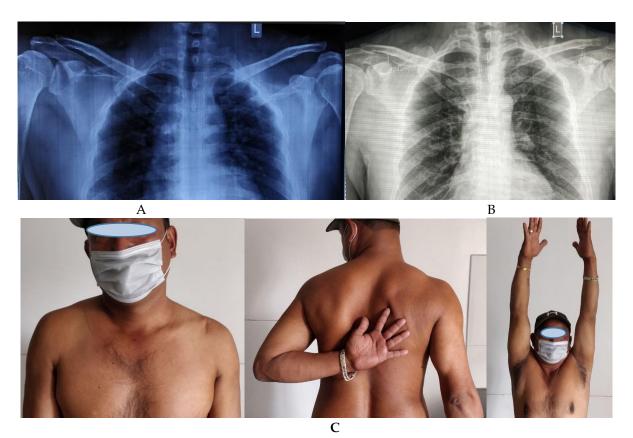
A. Pre-operative AP radiograph showing type V AC joint dislocation of left side; B. Final follow up (19 months) AP radiograph showing reduced CC distance to normal level as compare to normal side; C. Functional outcome showing loss of clinical step-off on the affected side and full range of motion 19 months following ACCR
